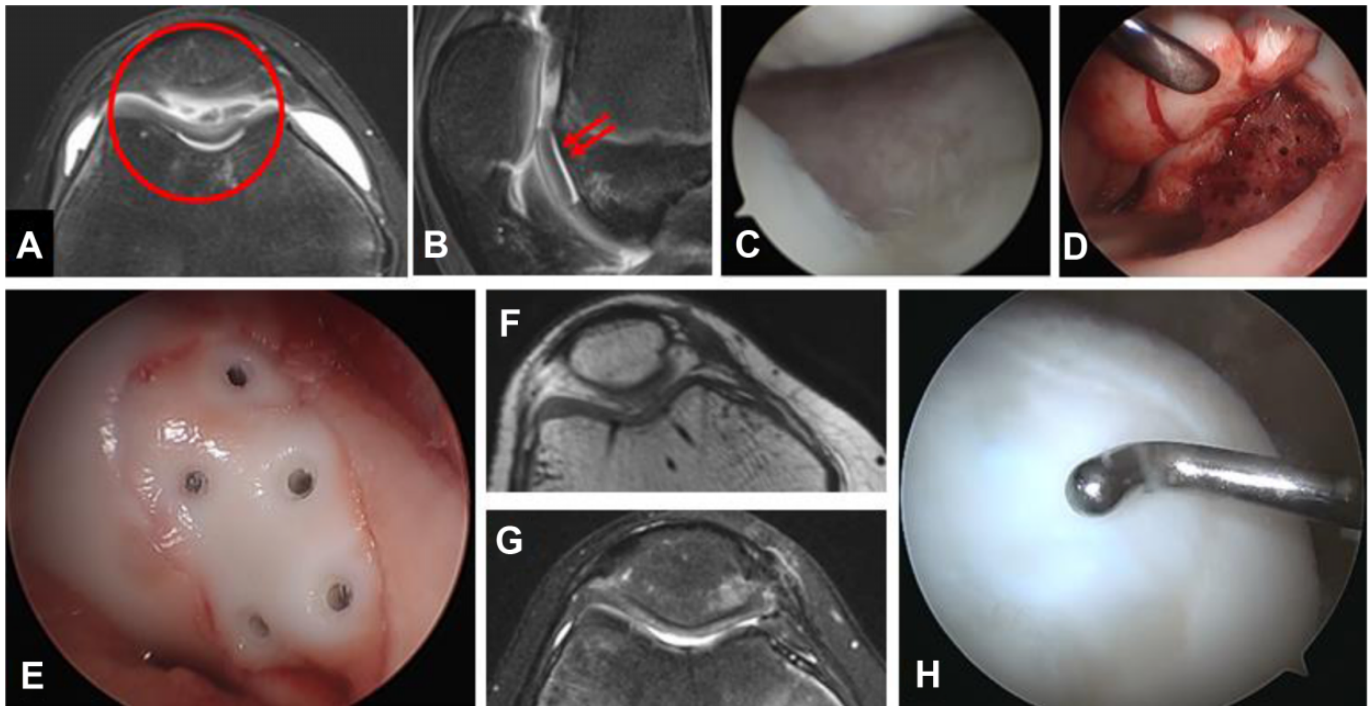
A 12-year-old male patient fell onto a flexed knee and presented with complaints of dull, achy anterior knee pain. (A) Axial and (B) sagittal T2-weighted turbo spin echo (TSE) magnetic resonance imaging (MRI) sequences with fat suppression (Magnetom Verio 3 T; Siemens) demonstrate a chondral-only shear fracture of the trochlea (circle), with an intact tidemark at the donor site (arrows). (C) Arthroscopic surgery and (D) arthrotomy revealed no viable bone on the back of the cartilage flap, which was treated with (E) drilling of the base and fixation with absorbable tacks. Three-month postoperative (F) axial proton density-weighted TSE and (G) axial T2-weighted TSE MRI sequences with fat suppression (Magnetom Verio 3 T) reveal restoration of the cartilage contour and early healing with the resolution of edema. (H) Second-look arthroscopic surgery at 12 months postoperatively for the removal of a small loose body of indeterminate origin revealed stable cartilage with an intact, healed interface between the fragment and donor site.
